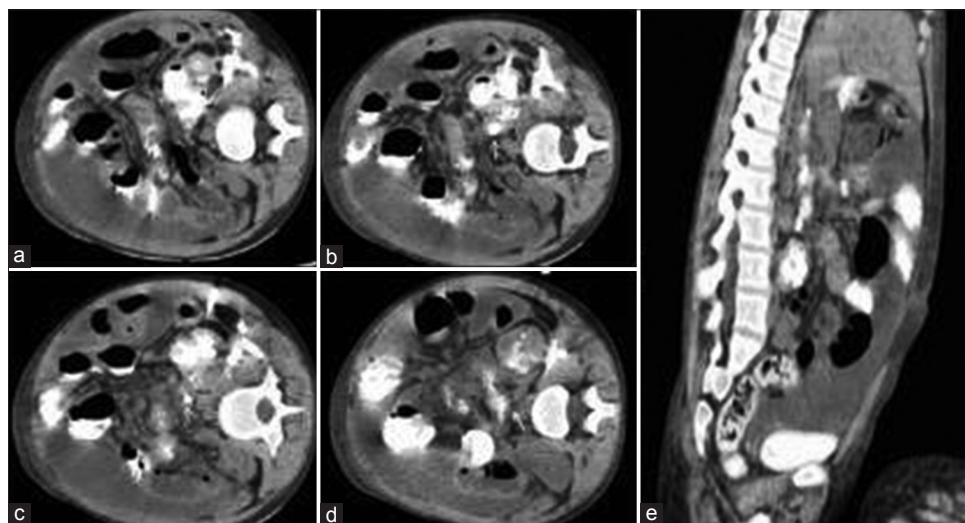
Left lateral decubitus multiple detector computed tomography images from above downward. (a-d) The passage of contrast agent from the right pelvicalyceal system to the duodenum (arrow) and sagittal multiplanar reformation of left lateral decubitus view. (e) The fistulous tract from the right pelvicalyceal system to the duodenum (black arrow)
